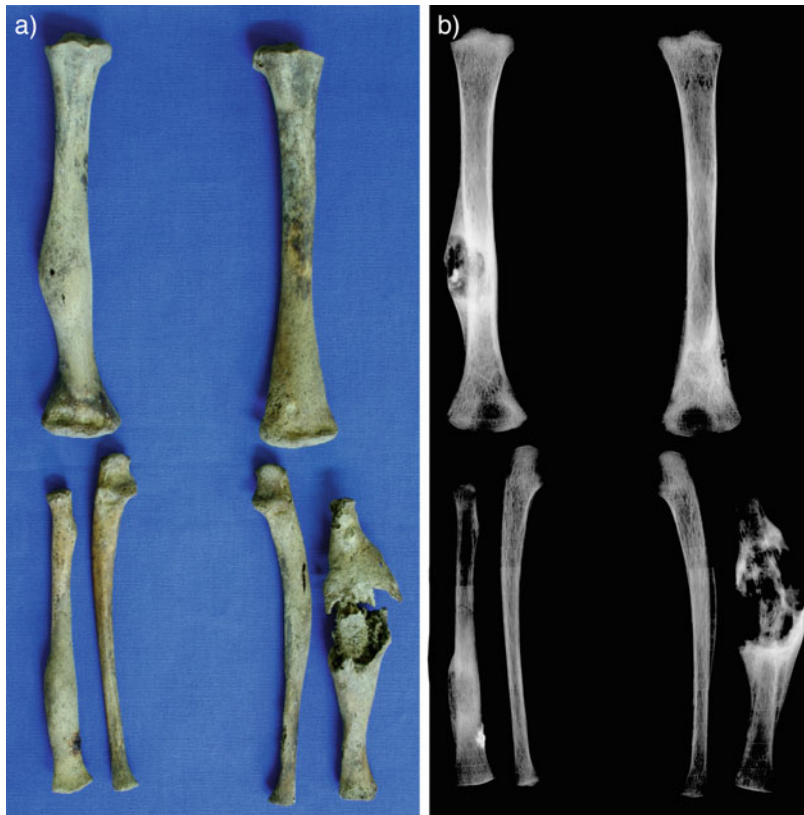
Photograph (a) and radiograph (b) of the arm bones of a 5–6-year-old child from the Kilkenny Union Workhouse. The bones are severely affected by osteomyelitis caused by tuberculosis
